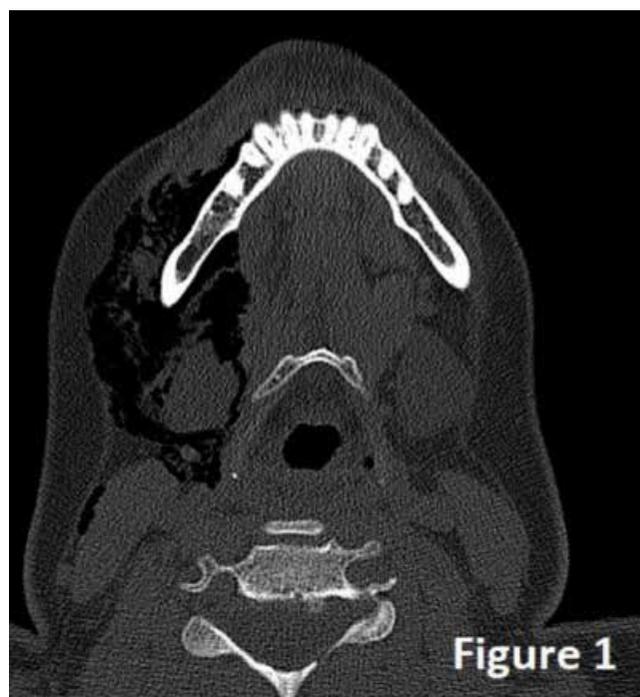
Free air images on the patient's maxillofacial CT
